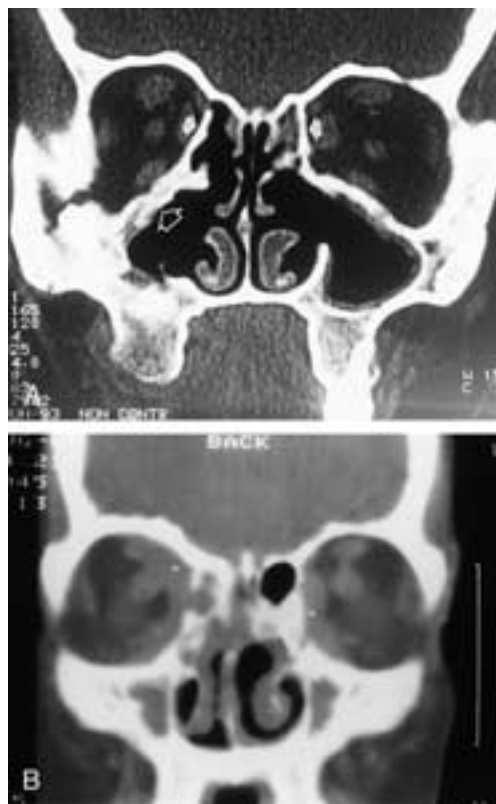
Osteitis of the paranasal sinus walls. A, Coronal CT image through the ethmoid sinus shows that the patient has had bilateral antrostomies, uncinectomies, and partial anterior ethmoidectomies. Note the pronounced thickening of the orbital floors bilaterally but more severely on the right side (*open arrow*). There is marked thickening of the lamina papyracea bilaterally (*solid arrows*). These changes are occasionally seen in patients who have undergone multiple surgical procedures in this area. B, Coronal CT image through the anterior ethmoid sinus in a patient with Wegener’s granulomatosis. Note the diffuse, pronounced bony thickening of the perimeter of the maxillary sinuses and lamina papyracea, as well as the presence of soft-tissue masses (*asterisks*) within the orbits.
